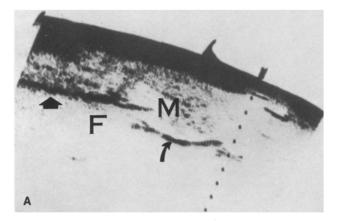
A–C. Case 16. Lymphoma. 50-year-old man with histiocytic lymphoma and shoulder pain. A Sagittal scan reveals unsuspected, relatively sonolucent, solid soft tissue mass (M) in proximal upper extremity, laterally. B Mass (M) is slightly larger on follow-up scan three months later, despite chemotherapy. White arrows indicate humeral cortex. C Plain radiographs show permeative destruction of humerus, consistent with lymphoma. No soft tissue mass is appreciated
